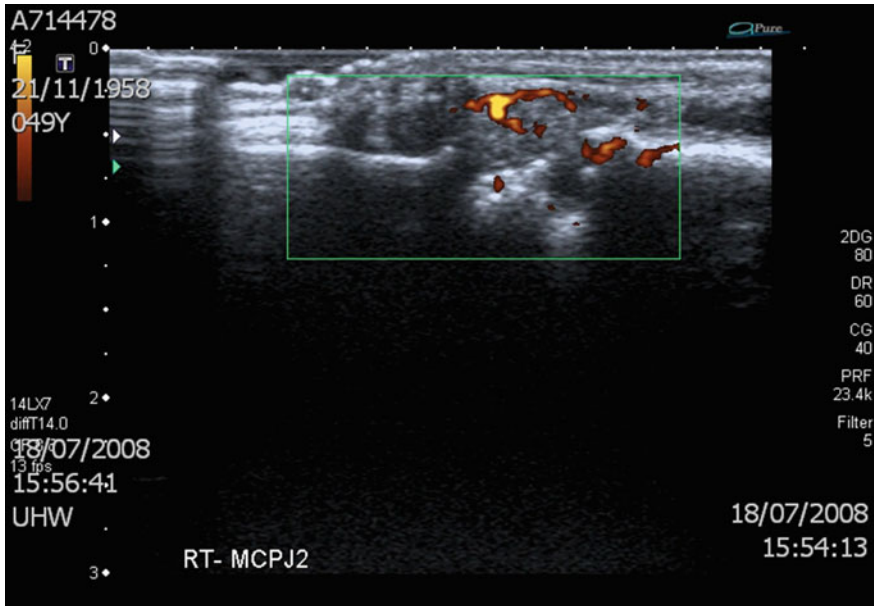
Acute synovitis of the right 2nd metacarpophlangeal joint with doppler indicating increased flow in the synovium
